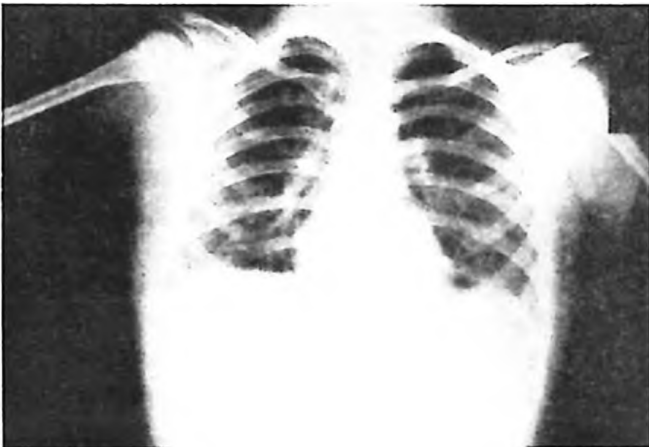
Chest roentgenogram showing bilateral paracardiac infiltrates together with bilateral minimal pleural effusion on the first hospital day.
